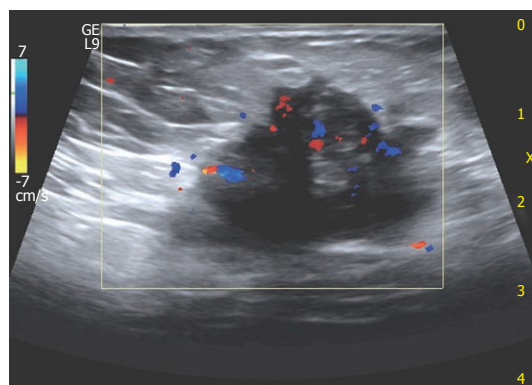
A 32-year-old woman with large scar endometrioma. Color Doppler exam displays multiple vascular poles entering the mass from different points and intralesional vascularisation.
